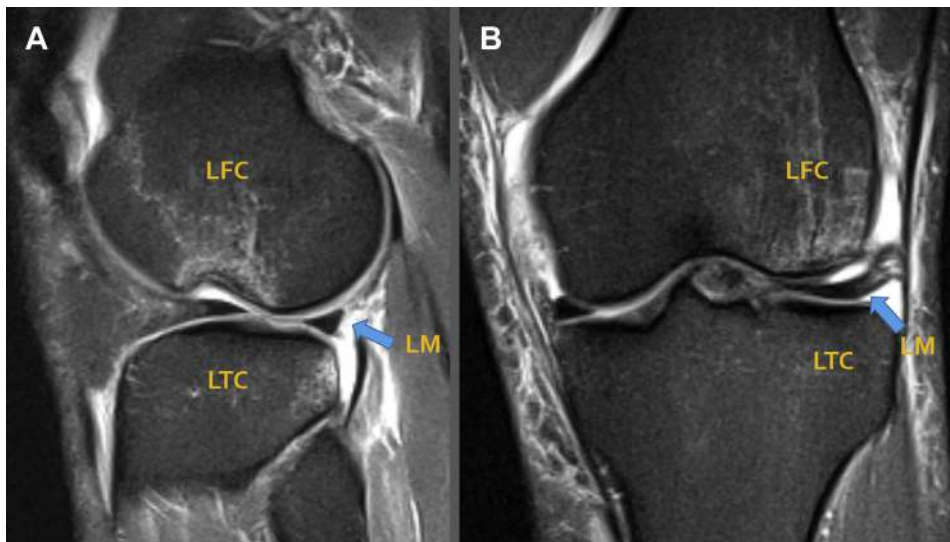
MRI scans of the left knee with “Hill-Sachs-like lesion” before surgery: (A) Sagittal view. Fracture and bone marrow oedema can be seen on lateral femoral condyle (LFC). (B) Coronal view. LFC fracture and bone marrow oedema can be seen as well. Lateral Meniscus (LM) is elevated without contact with LFC nor Lateral Tibial Condyle (LTC). Such lesion leads to bony knee instability, causing the risk of ACL reconstruction failure and meniscal tears to increase. What is more, the articulation area is reduced and lateral meniscus load distribution function is decreased, which alters knee biomechanics and increases the risk of osteoarthritis (OA).
